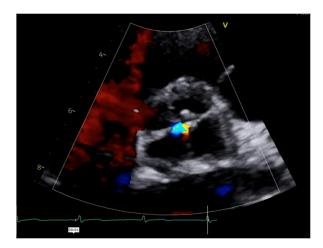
A color Doppler echocardiogram's short-axis view shows a quadricuspid aortic valve.
